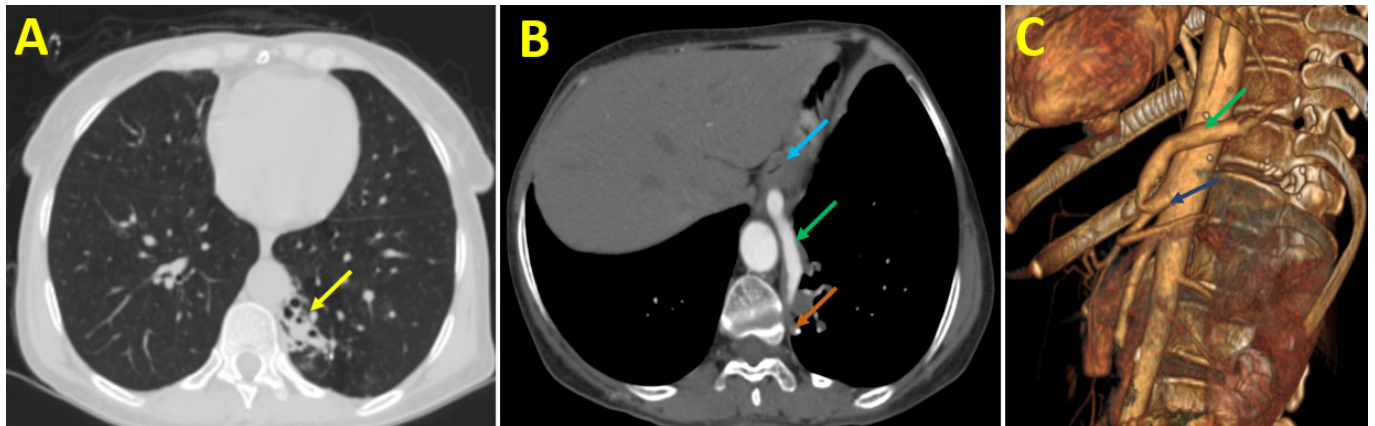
Contrast-enhanced CT scan of the lower chest. A: Lung window; B: mediastinal window shows heterogeneous patchy area of consolidation involving the medial aspect of the posterior segment of the left lower lobe abutting the medial pleura with internal bronchiectatic changes (yellow arrow) showing coarse calcification (orange arrow) and there is aberrant vessel (green arrow) supplying this pulmonary lesion ascending from the abdominal cavity through the esophageal hiatus posterior to the gastro-esophageal junction (blue arrow); C: volume rendered image showing the aberrant vessels arising from the celiac trunk (blue arrow).
